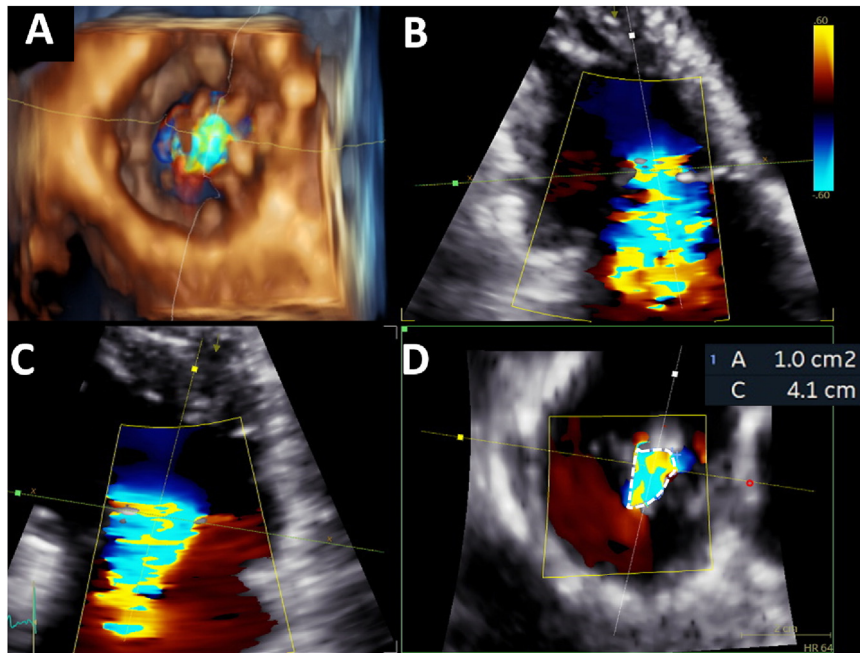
Effects of the orientation of the 2D cut plane on the measurement of the VC diameter. (A) Transverse section of a transthoracic 3D color Doppler data set to show the VC of the regurgitant jet from the ventricular perspective. The shape is elliptical. (B and C) Four-chamber and anteroposterior longitudinal cut planes obtained by slicing the data set in (A) (yellow line, four-chamber view; white line, 2D view at 90° from the four-chamber view). The diameter of the VC in the four-chamber is smaller than the one that could be measured in its orthogonal view. Data sets are intentionally sliced to facilitate planimetry of the VCA. (D) Planimetry of the VC drawn on a transverse cut plane obtained by slicing the 3D color data set at the level of the VC and perpendicular to the longitudinal axis of the regurgitant jet. A, Area; C, circumference.
